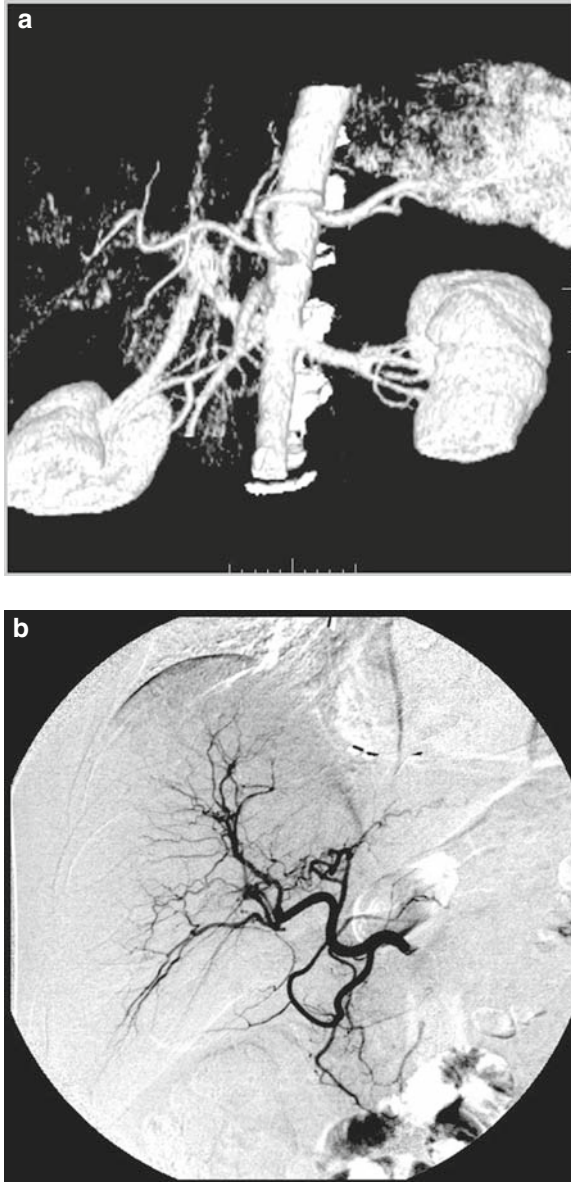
(a) CT arteriogram demonstrating conventional hepatic artery anatomy. (b) Common hepatic arteriogram demonstrates similar appearance of the common hepatic artery.
